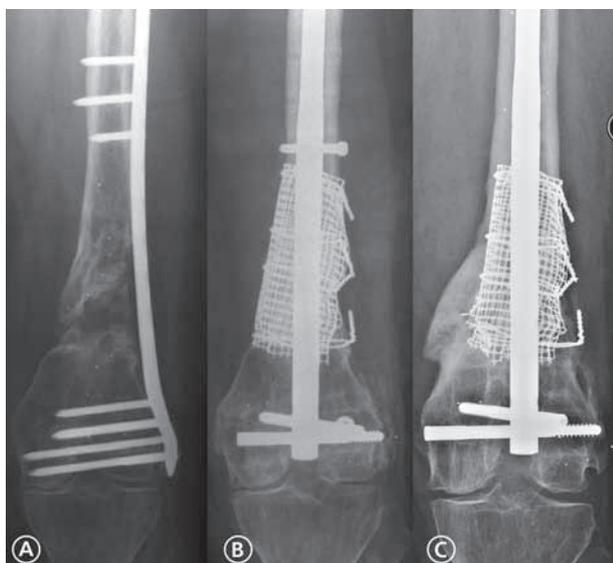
Sequential radiographs of the left distal femur of a 60-year-old female whose femoral non-union and defect were treated with acute lengthening and impaction grafting (Case 3). A) Preoperative AP radiograph of the non-union. B) Immediate postoperative AP radiograph of the reconstruction. C) Two year post-reconstruction AP radiograph demonstrating maintenance of reduction/lengthening and abundant new and remodeled periosteal bone formation.
